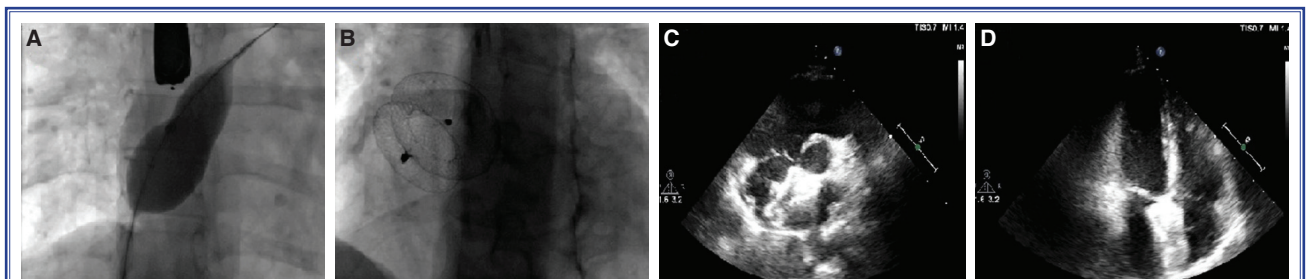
(A) Fluoroscopic view of the sizing balloon. (B) Fluoroscopic view of the atrial septal occluder device. (C, D) Transthoracic parasternal short and apical long axis view of the atrial septal occluder device.
